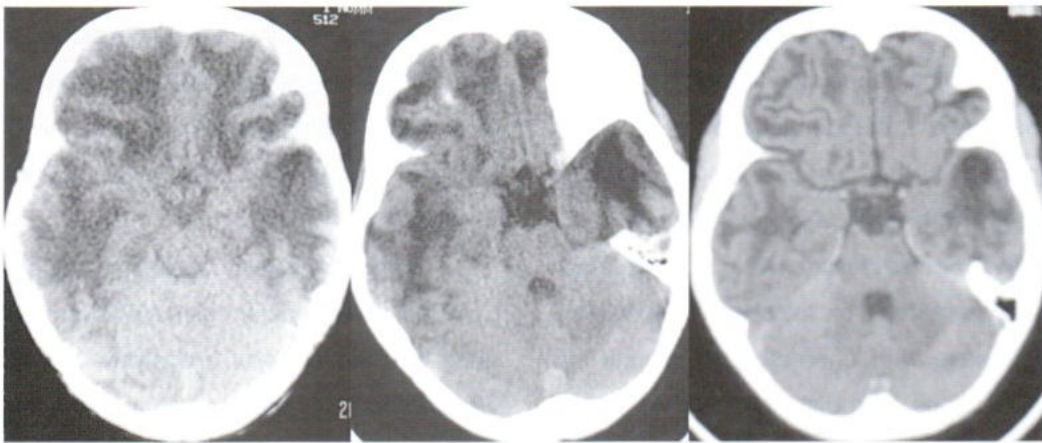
Transaxial CT in 1994 (a), 1997 (b) and 2004(c) (from left to right) shows diffuse cerebral white matter low density with a left anterior temporal subcortical cyst and progression of cerebral atrophy.
